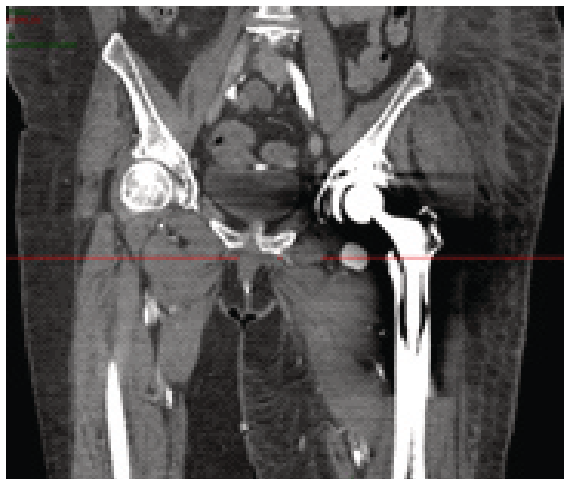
Axial CTA demonstrating a 16.9 × 20.2 mm pseudoaneurysm adjacent to the left hip prosthesis.
